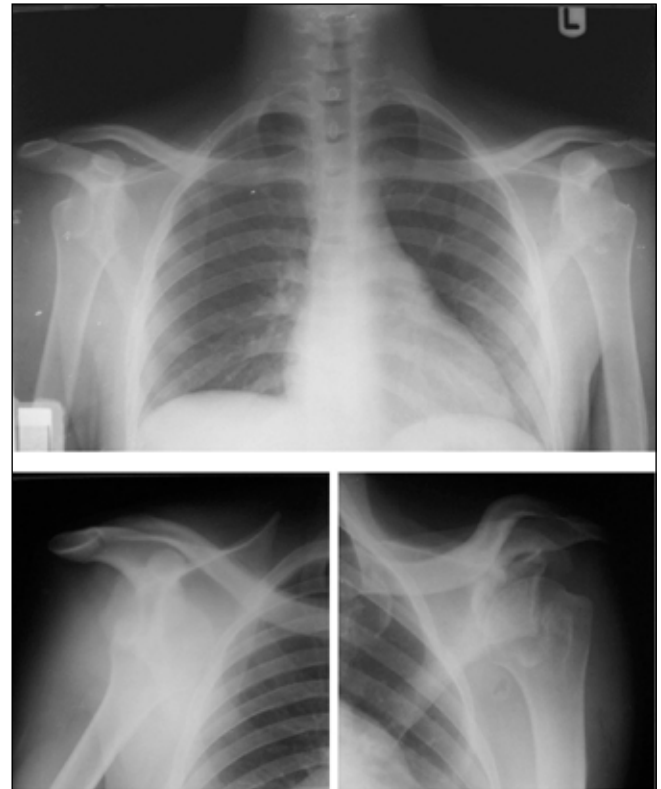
Radiographs of the chest and shoulders in a 35-year-old man with bilateral sub-coracoid anterior dislocation of the shoulders.
